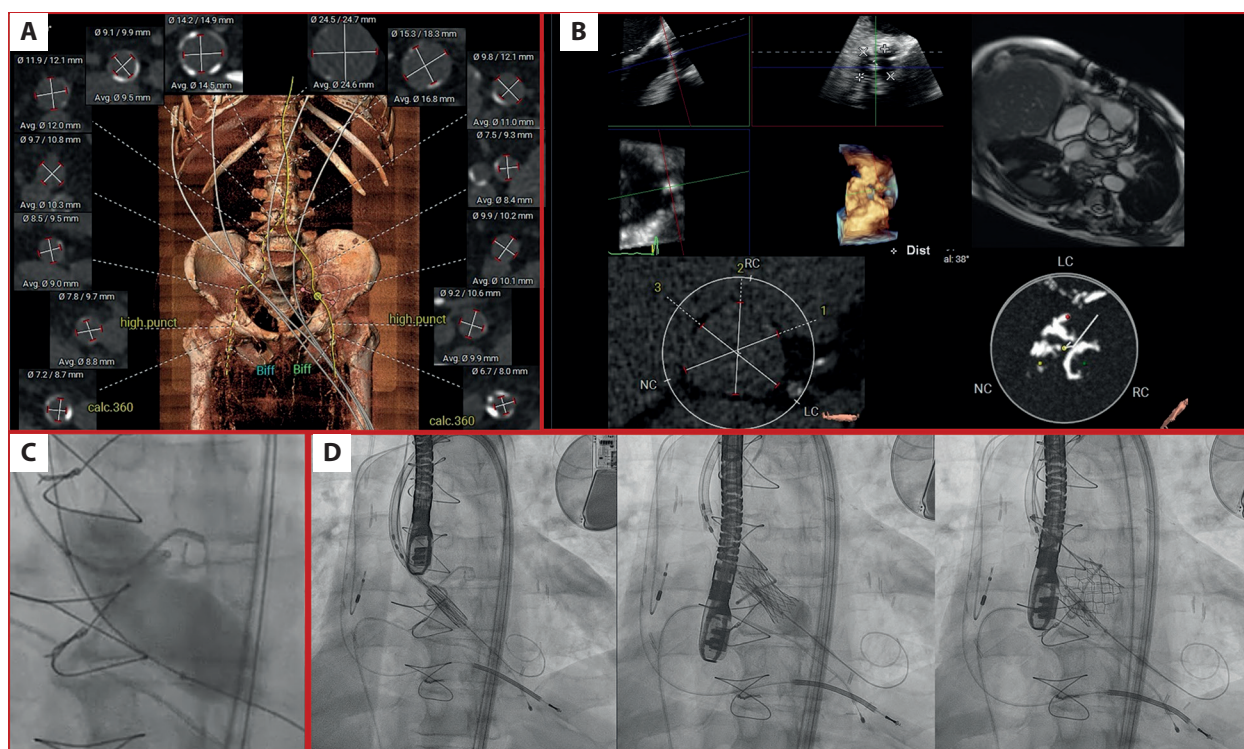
Main aspects of zero-contrast TAVI preparation and execution. A. Non-contrast CT for assessment of access site calcification. B. Transesophageal 3D echocardiogram, non-contrast enhance cardiac NMR and non-contrast CT for assessment of valve anatomy and annulus size calculation. C. Balloon valvuloplasty with a visible notch on the balloon suggesting proper sizing of the valve. D. TAVI zero contrast valve positioning and implantation based on location of catheters in non coronary and left coronary cusps
